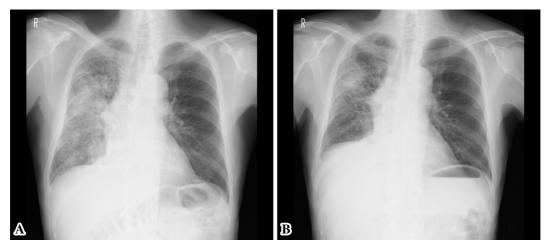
A: Chest X-ray before crizotinib therapy showed consolidation and ground glass opacity in the right midlung. B: Chest X-ray showed a reduction in tumor size on day 6.
